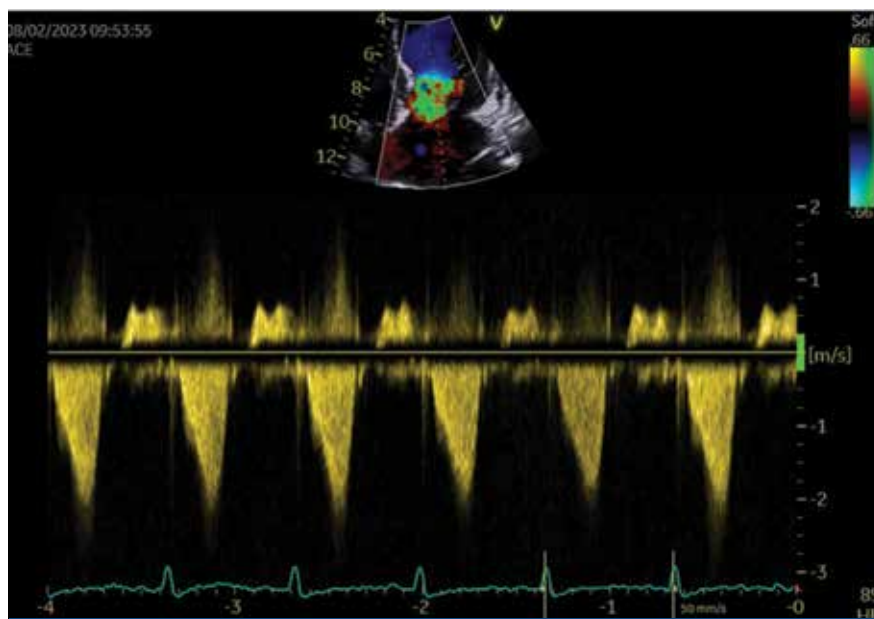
Apical four chamber view of left ventricular outflow tract obstruction.
